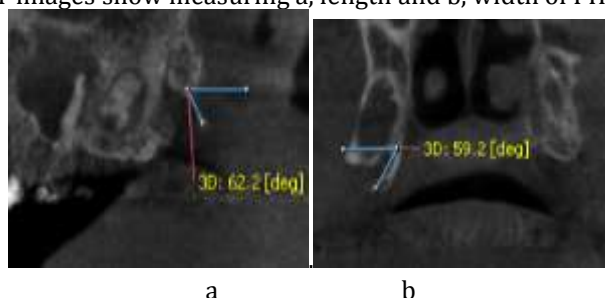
a,b, MPR CBCT images show angulation measurement of PH a, in the sagittal plane b, in the coronal plane.
